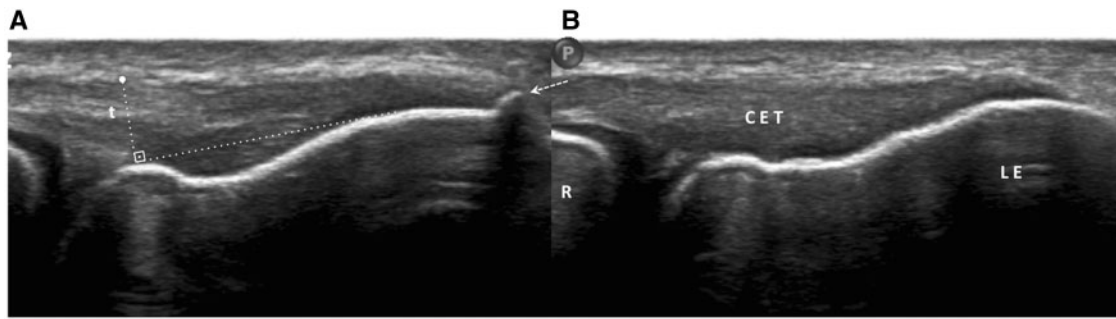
Longitudinal ultrasound imaging for the lateral epicondyle in a 42-year-old man with refractory lateral epicondylitis. Measurement (t) of the mildly thickened common extensor tendon (CET) is shown. Note the cortical spur (arrow) at its insertion (A). Normal side (B). R, radial head.
